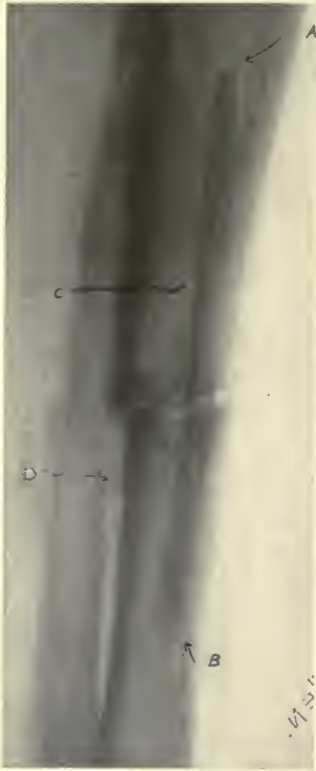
Ununited fracture of a tibia 4 months after the insertion of inlay graft *AB*. *C* is piece of broken silver wire inserted at a previous unsuccessful operation. *D* is screw hole of a previous Lane's plate. The union from the inlay is firm at the time this X-ray was made the patient is walking on the limb. Nevertheless, there is no callus at the ends of the fragments.
